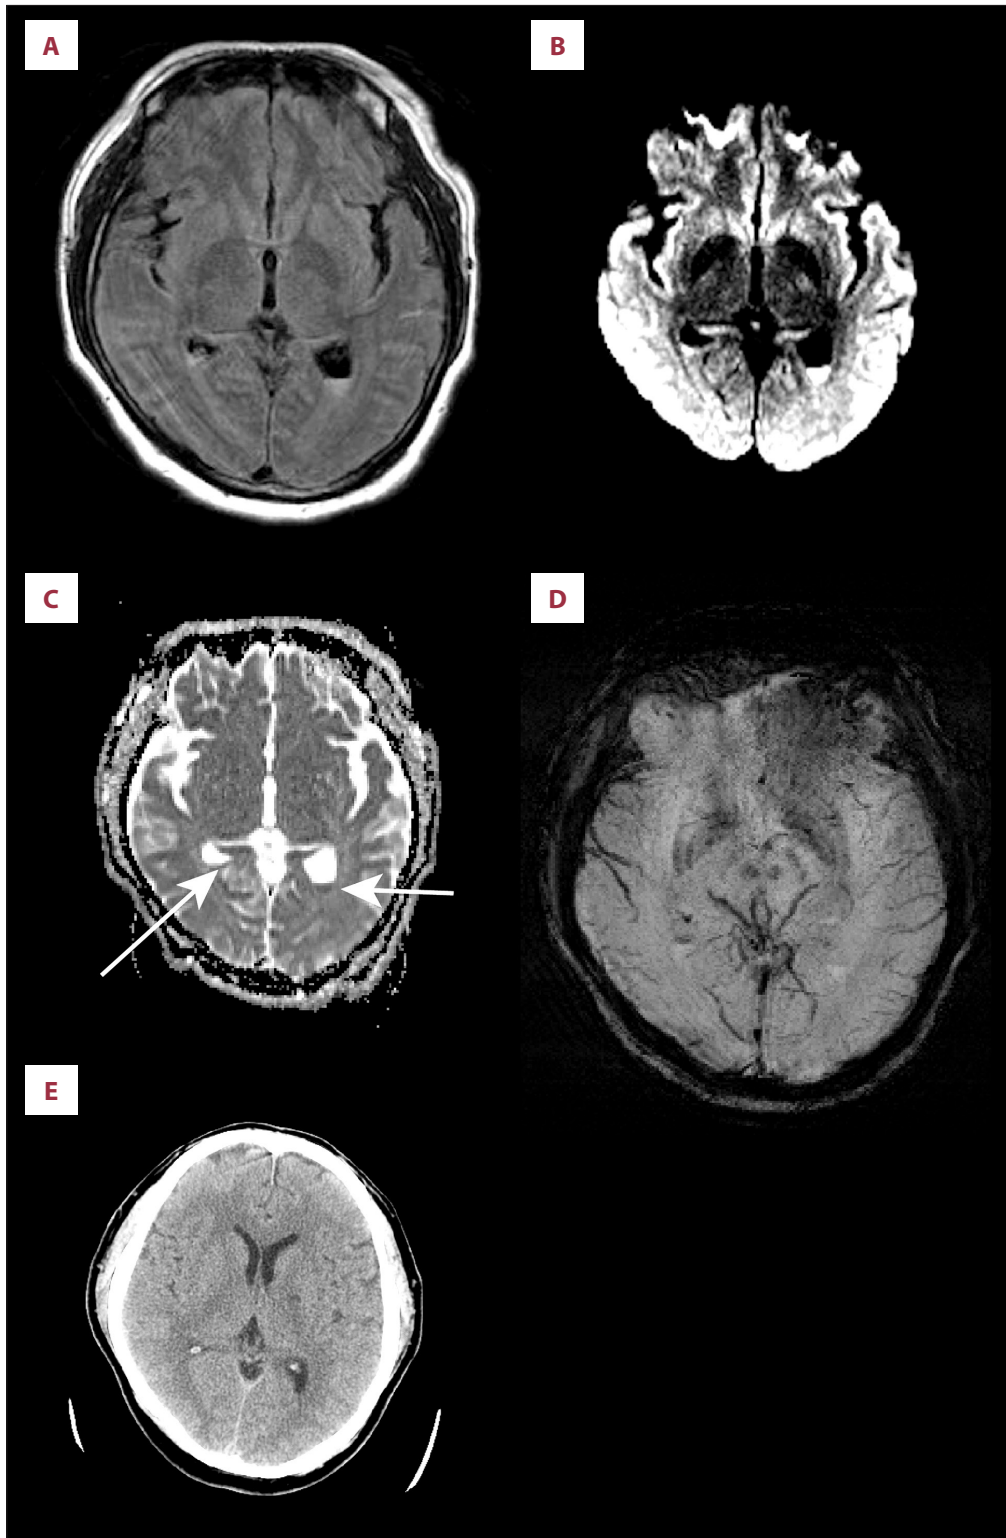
Brain magnetic resonance imaging (MRI) findings on the day of hospital admission. (A) Fluid-attenuated inversion recovery (FLAIR). (B) Diffusion-weighted MRI (DW MRI). (C) Axial apparent diffusion coefficient (ADC) image (a companion image to Figure 1B); the white arrows show the somewhat triangular and crescent-shaped dark areas representing infected proteinaceous material/pus. (D) The susceptibility-weighted (SW) MRI. (E) Non-contrast computed tomography (CT) head image showing the absence of acute hemorrhage/blood.
